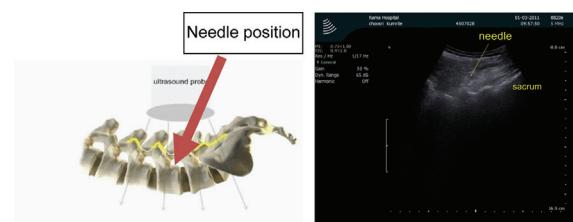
Under ultrasound guidance, needle-tip is identified comparing with the ultrasound view on the right
